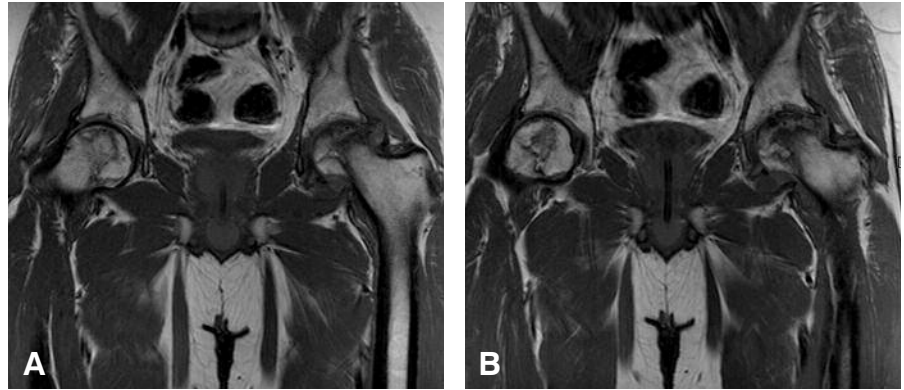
Coronal MR images of the pelvis show the osteonecrosis of the (A) left and (B) right femoral heads.
